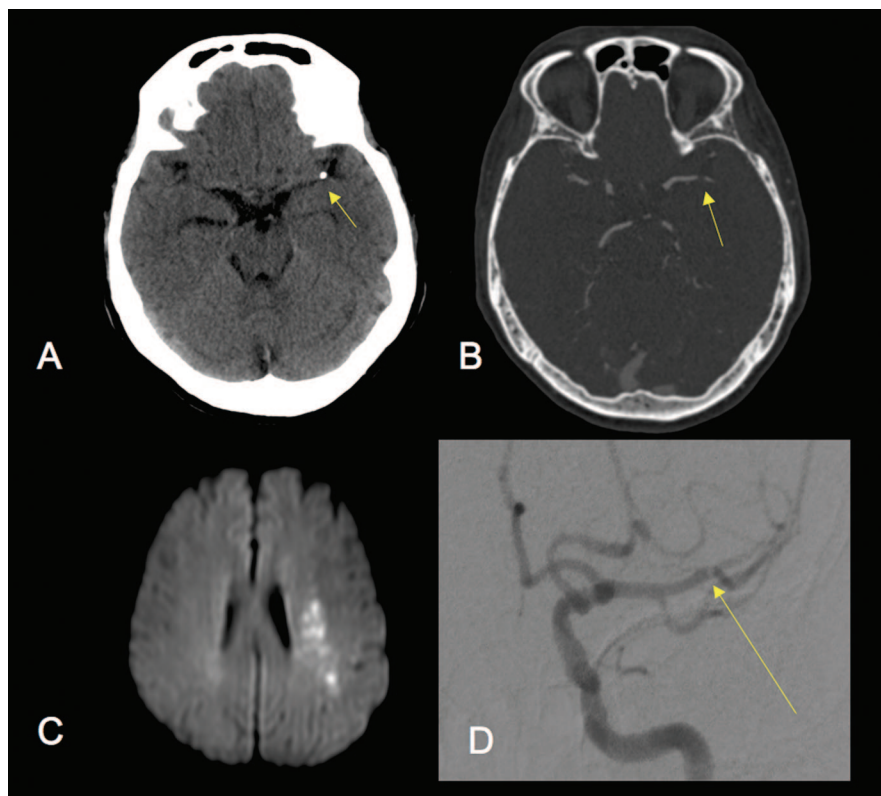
(A) Noncontrast CT scan of the head showing a calcified embolus within the left middle cerebral artery (MCA). (B) CT angiography showing the calcified embolus with poor distal flow. (C) Diffusion-weighted MRI shows the acute ischemic lesion in the left MCA territory. (D) Digital subtraction angiography showing the calcific embolus in the distal M1 with delayed filling in the superior division of MCA.
